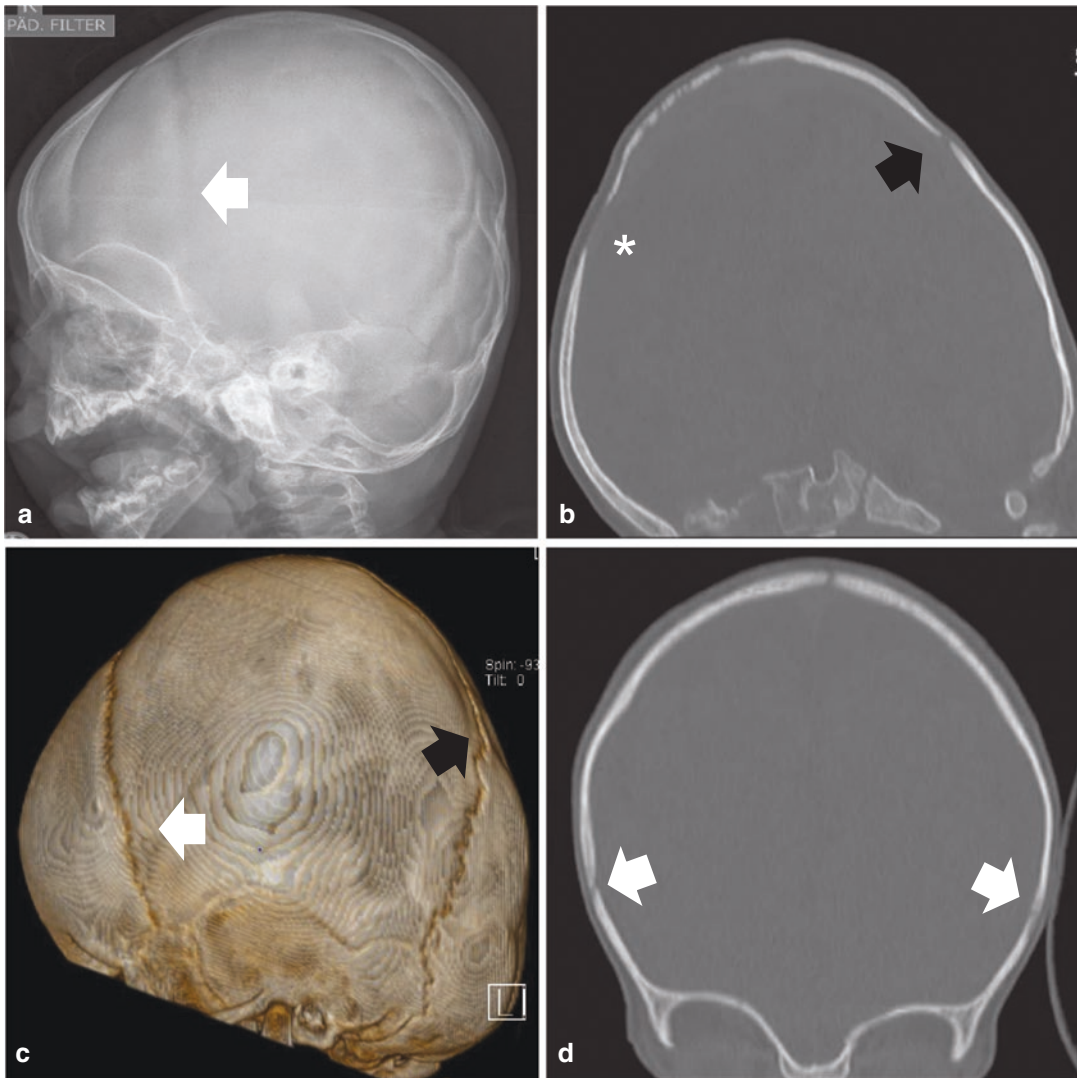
9-Month-old boy with coronal craniosynostosis. Lateral plain skull radiography (a), lateral (b) and coronal (d) 2D CT images in bone window, and lateral 3D CT-image (VRT) (c) show premature bilateral fusion of coronal sutures (white arrows) with resulting turricephaly.
